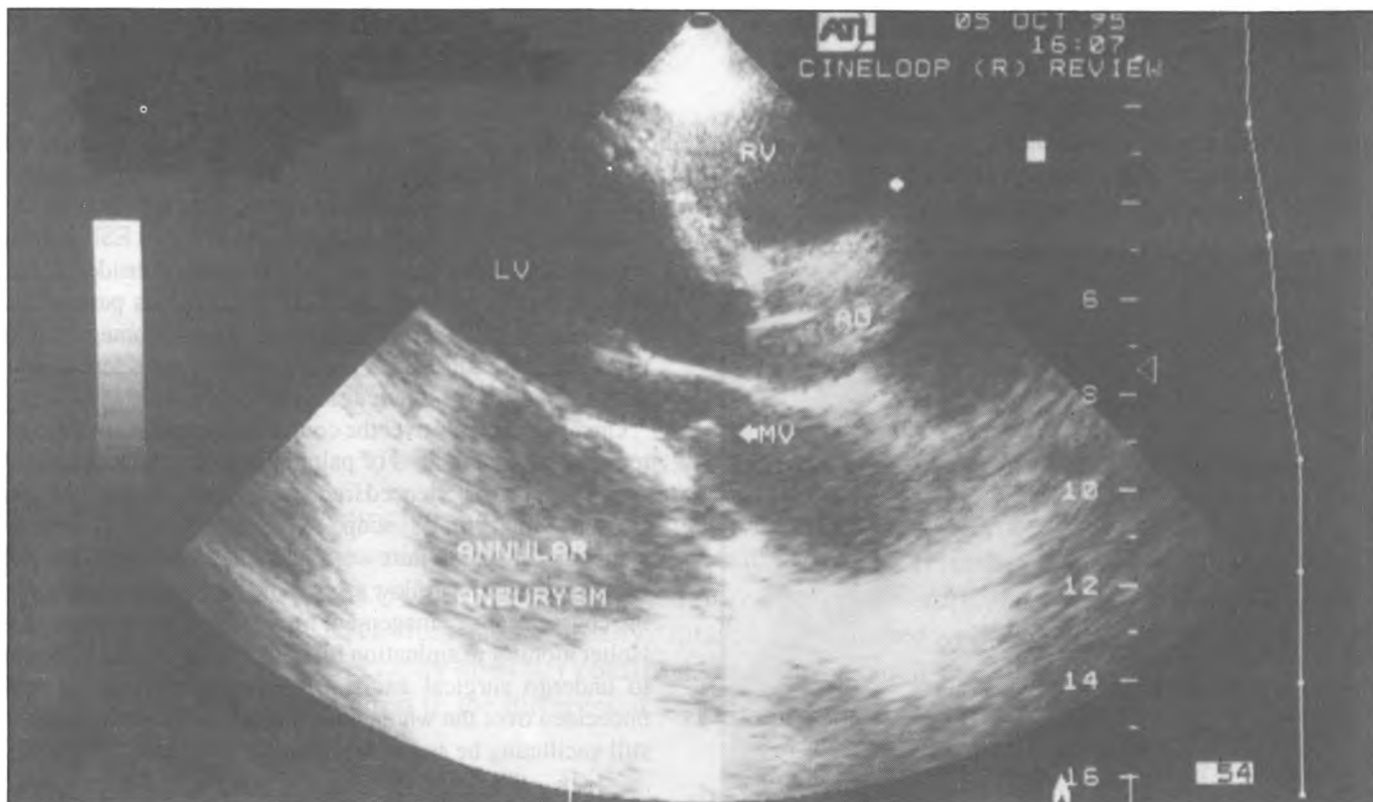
Four chamber echocardiographic view showing an annular subvalvular left ventricular aneurysm (AN) seen as a large bulge on the lateral surface of the left ventricle (LV). Communications with the left ventricular cavity and the rather squashed left atrium are evident. RV-right ventricle, RA-right atrium, Ao-aorta. Note: the left atrium is not labelled.
